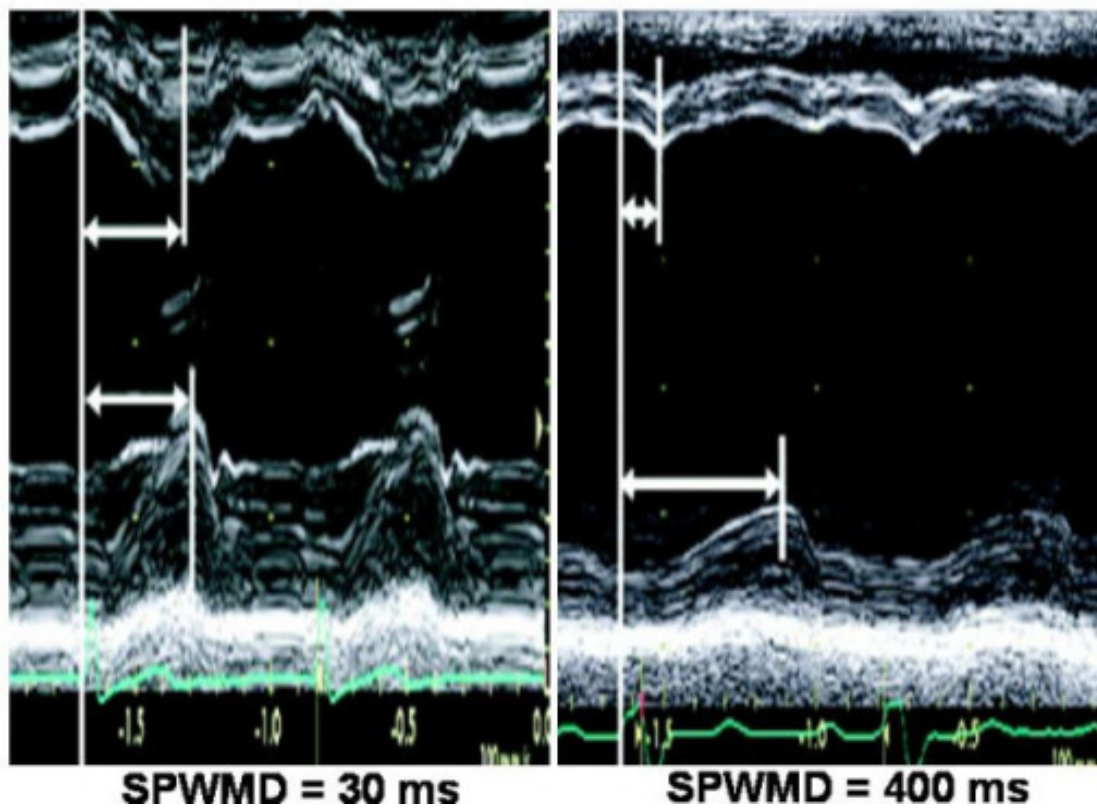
Measurement of septal to posterior wall delay by Mode echocardiography
